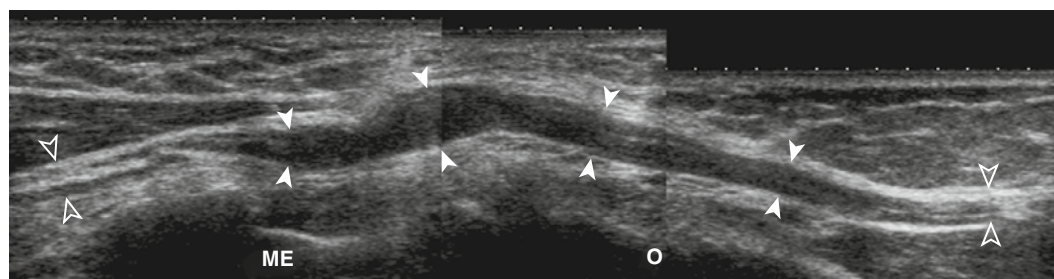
PATHOLOGIC ULNAR NERVE AT THE CUBITAL TUNNEL LEVEL. Composed, long-axis, 5- to 14-MHz ultrasound image over the posteromedial elbow shows a fusiform and elongated enlarged ulnar nerve (*closed arrowheads*) at the level of the medial epicondyle (ME) and olecranon (O), along with the normal proximal and distal ulnar nerve (*open arrowheads*).
